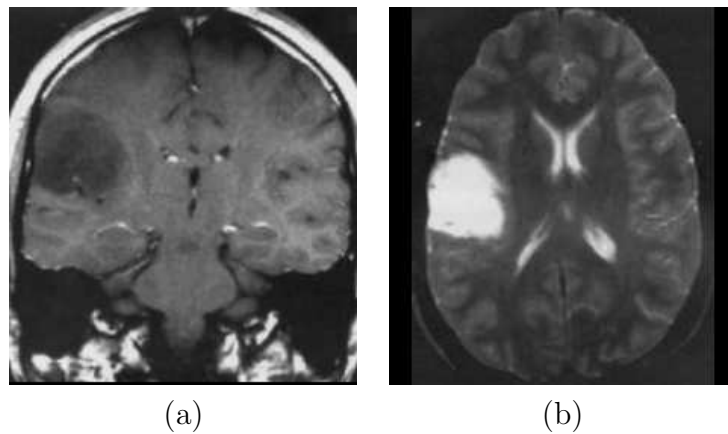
Diffuse low grade astrocytoma (Grade II). a) Coronal slice of contrast enhanced T1-weighted image. No enhancement is present with contrast enhancement. b) Axial slice of T2-weighted image of the same tumor without surrounding edema [Emedicine, 2005].
